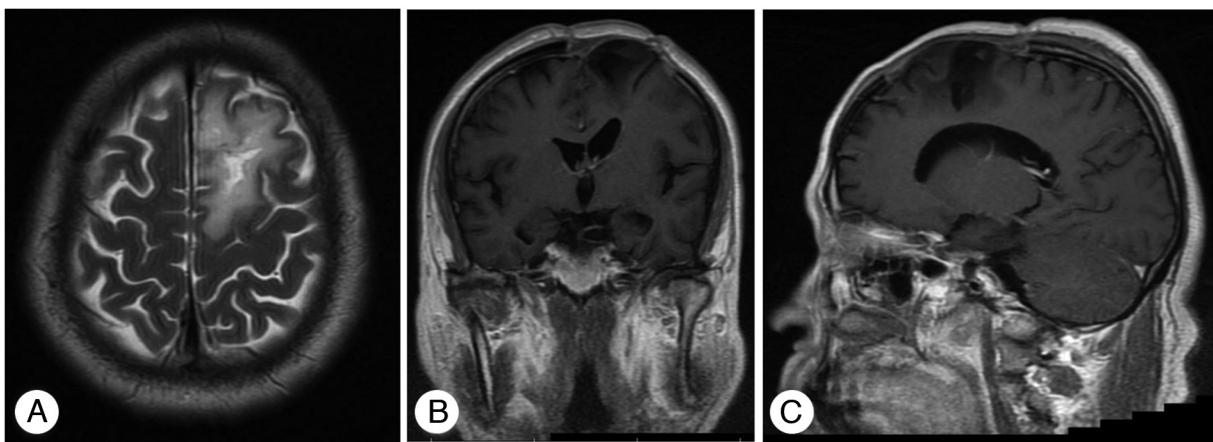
Follow-up magnetic resonance imaging scans 3 months postoperatively. (A) Axial T2-weighted image demonstrating marked reduction of edema in the frontal lobe. (B) Contrast-enhanced coronal T1-weighted image showing no residual contrast-enhancing lesion in the surgical area. (C) Contrast-enhanced sagittal T1-weighted image confirming the absence of contrast-enhancing lesions at the operative site.
